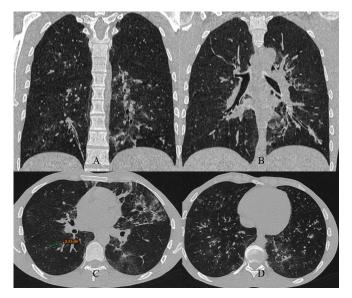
Chest HRCT images of patient 1
